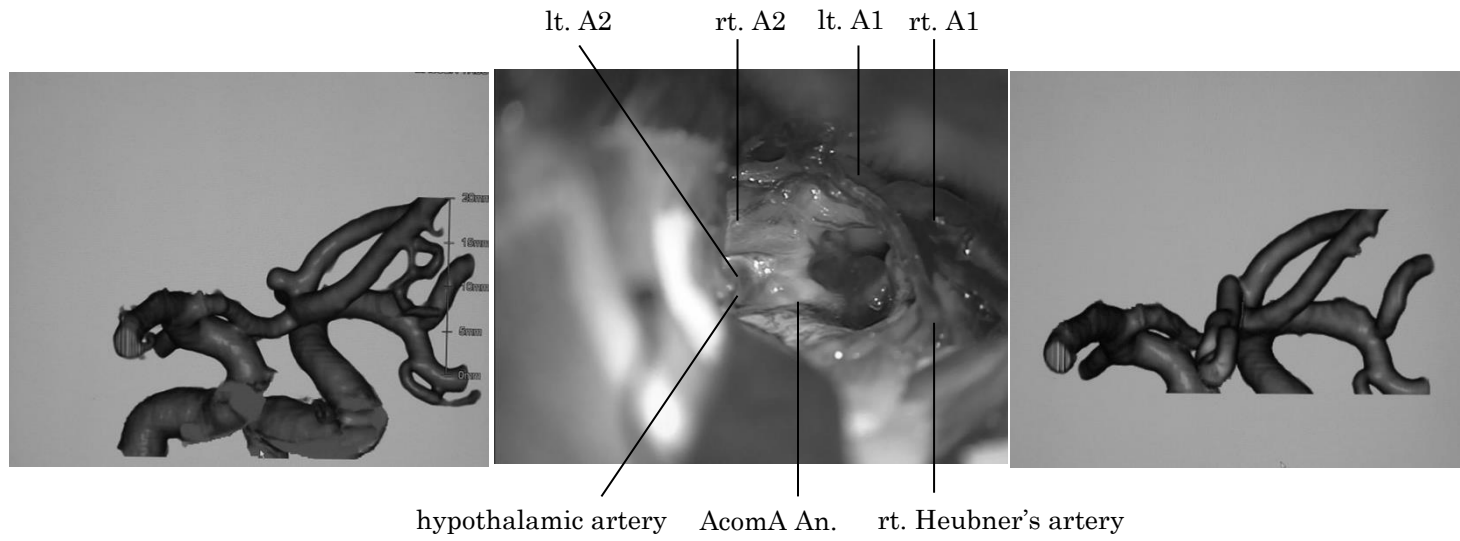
A 65-year-old woman with a dorsal projection AcomA An (A). An AcomA plane was open to left side. Rt. PA was performed. Intraoperative findings clearly revealed an AcomA complex, hypothalamic artery, and An.(B). A complete obliteration of the An. and preservation of each branches was confirmed by postoperative CTA (C).
